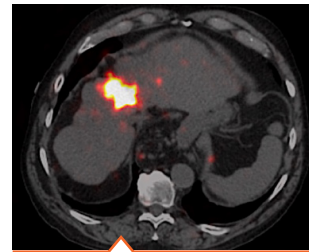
Post-Y90 PET-CT demonstrates the highly focal delivery to the tumor and minimal uptake to the surrounding hepatic parenchyma achieved with PEDD.
